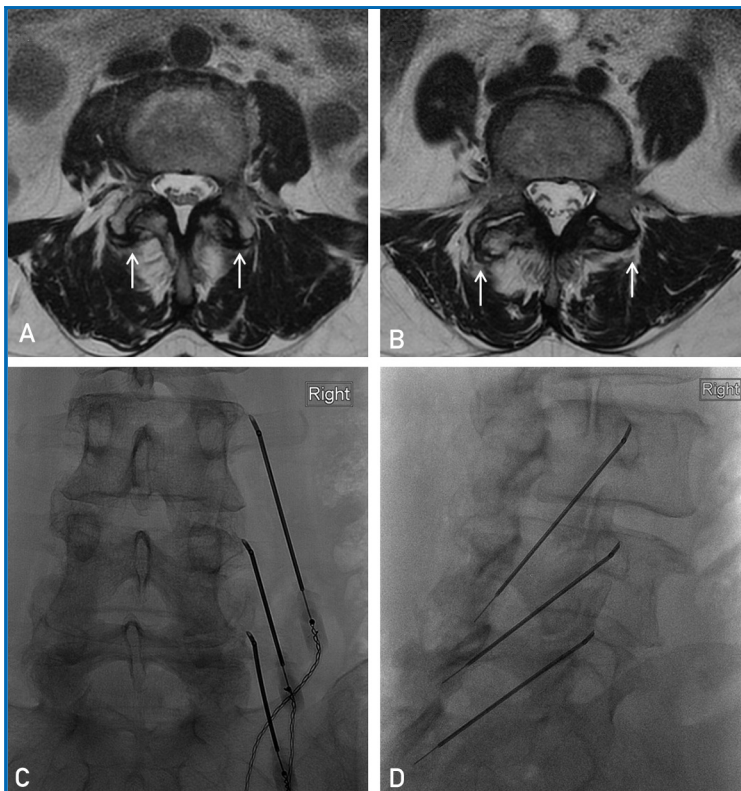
Axial T2-weighted magnetic resonance images showing facet joint arthritis at the L3-4 (A) and L4-5 (B) levels (arrows). Selected fluoroscopic images (C and D) showing one of the patient's prior radiofrequency ablations.
